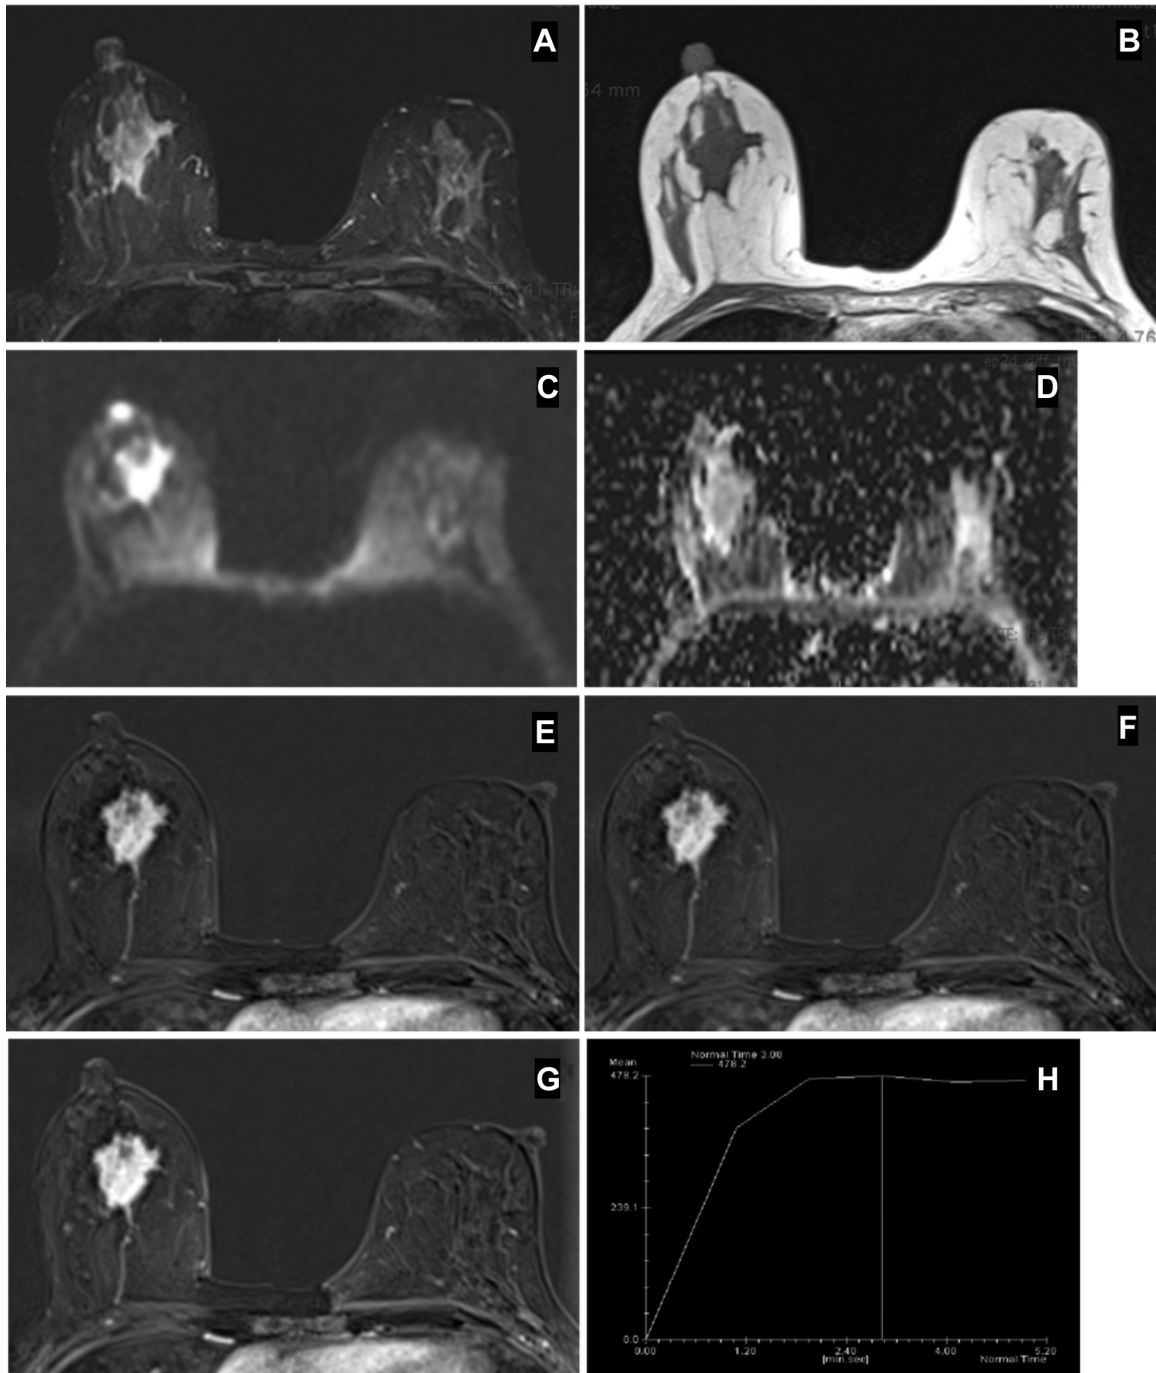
Magnetic resonance imaging findings. A, B: Short tau inversion recovery and T1-weighted imaging sequences revealing the right breast lesion: Intermediate hyperintense on T2-weighted imaging and hypointense on T1-weighted. Left quadrantectomy outcomes are shown. C, D: The lesion did not restrict diffusion. E-G: After administration of contrast medium, the lesion presented early and intense enhancement. H: The lesion showed a type II signal intensity/time curve.
